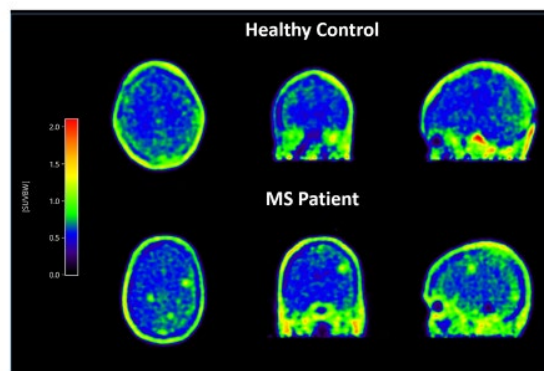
A ^{11}C SMW139-PET SUV image of one healthy control and one MS patient (Adapted from the literature³⁴).
